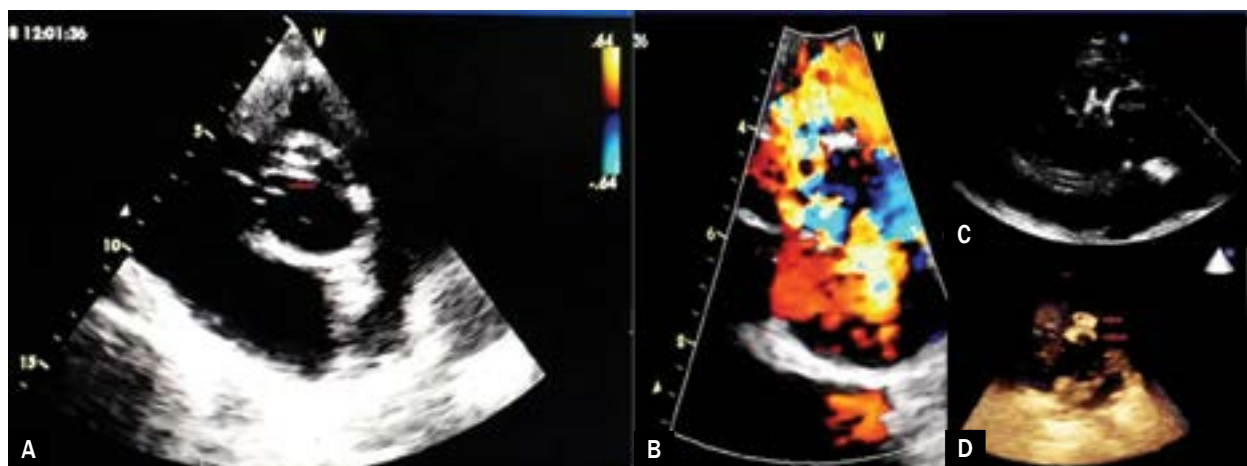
Transthoracic echocardiography showing right sinus of Valsalva communicating into right ventricle (red arrow; A); colour Doppler showing the ruptured sinus of Valsalva aneurysm (RSOVA) in right ventricle (B); well apposed device with both the discs (2D echo – white arrow; C) (3D; D)
